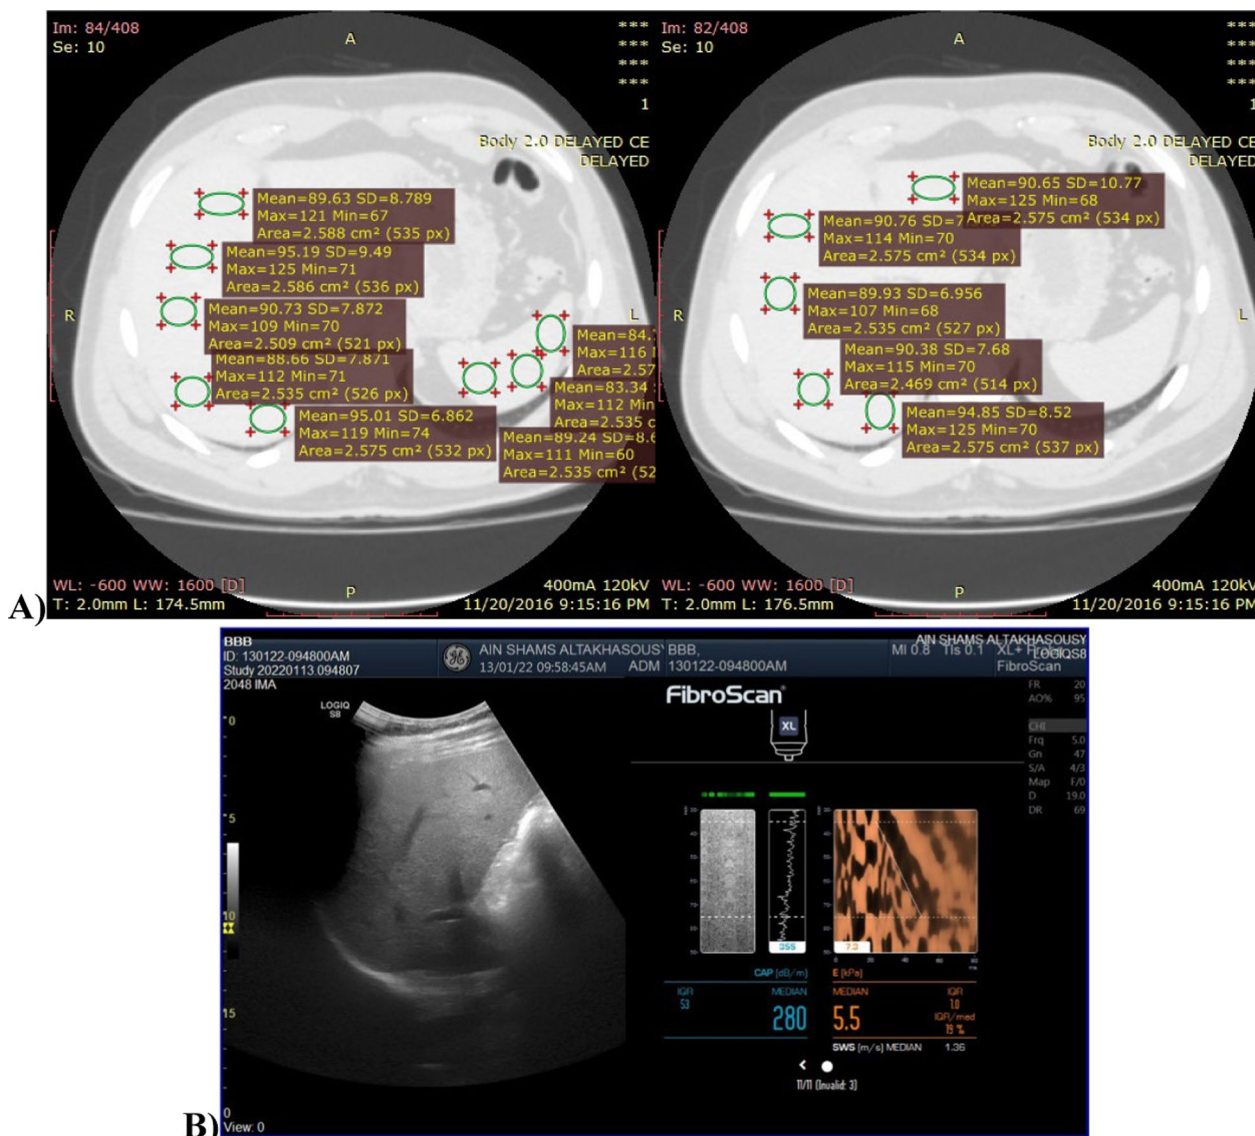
A male patient 33 year's old, candidate for orthotopic living donor liver transplantation. His initial evaluation shows no visible steatosis according to traditional abdominal ultrasound and laboratory result. CT transplantation protocol was done with assessment of liver attenuation index (LAI) which was done in delayed phase showed (LAD=10), which according to our cutoff value result of 9, suspected steatosis is 0–10%. Fibroscan study was done, and assessment of controlled attenuation parameter (CAP) showed CAP = 280 db/m, which keep with S2 grade that equals to 0–10% steatosis. Liver biopsy was done and showed 10% steatosis, LAI result only is true positive to biopsy result. A CT scan. B Fibroscan
